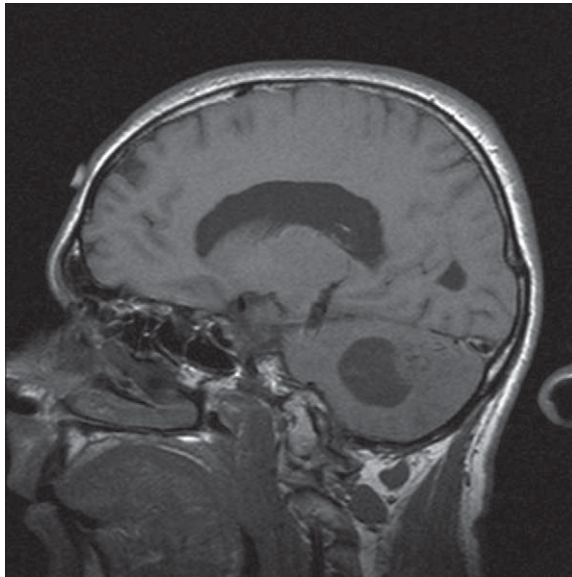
Sagittal T1-weighted MRI of a patient with a haemangioblastoma in the right cerebellar hemisphere
